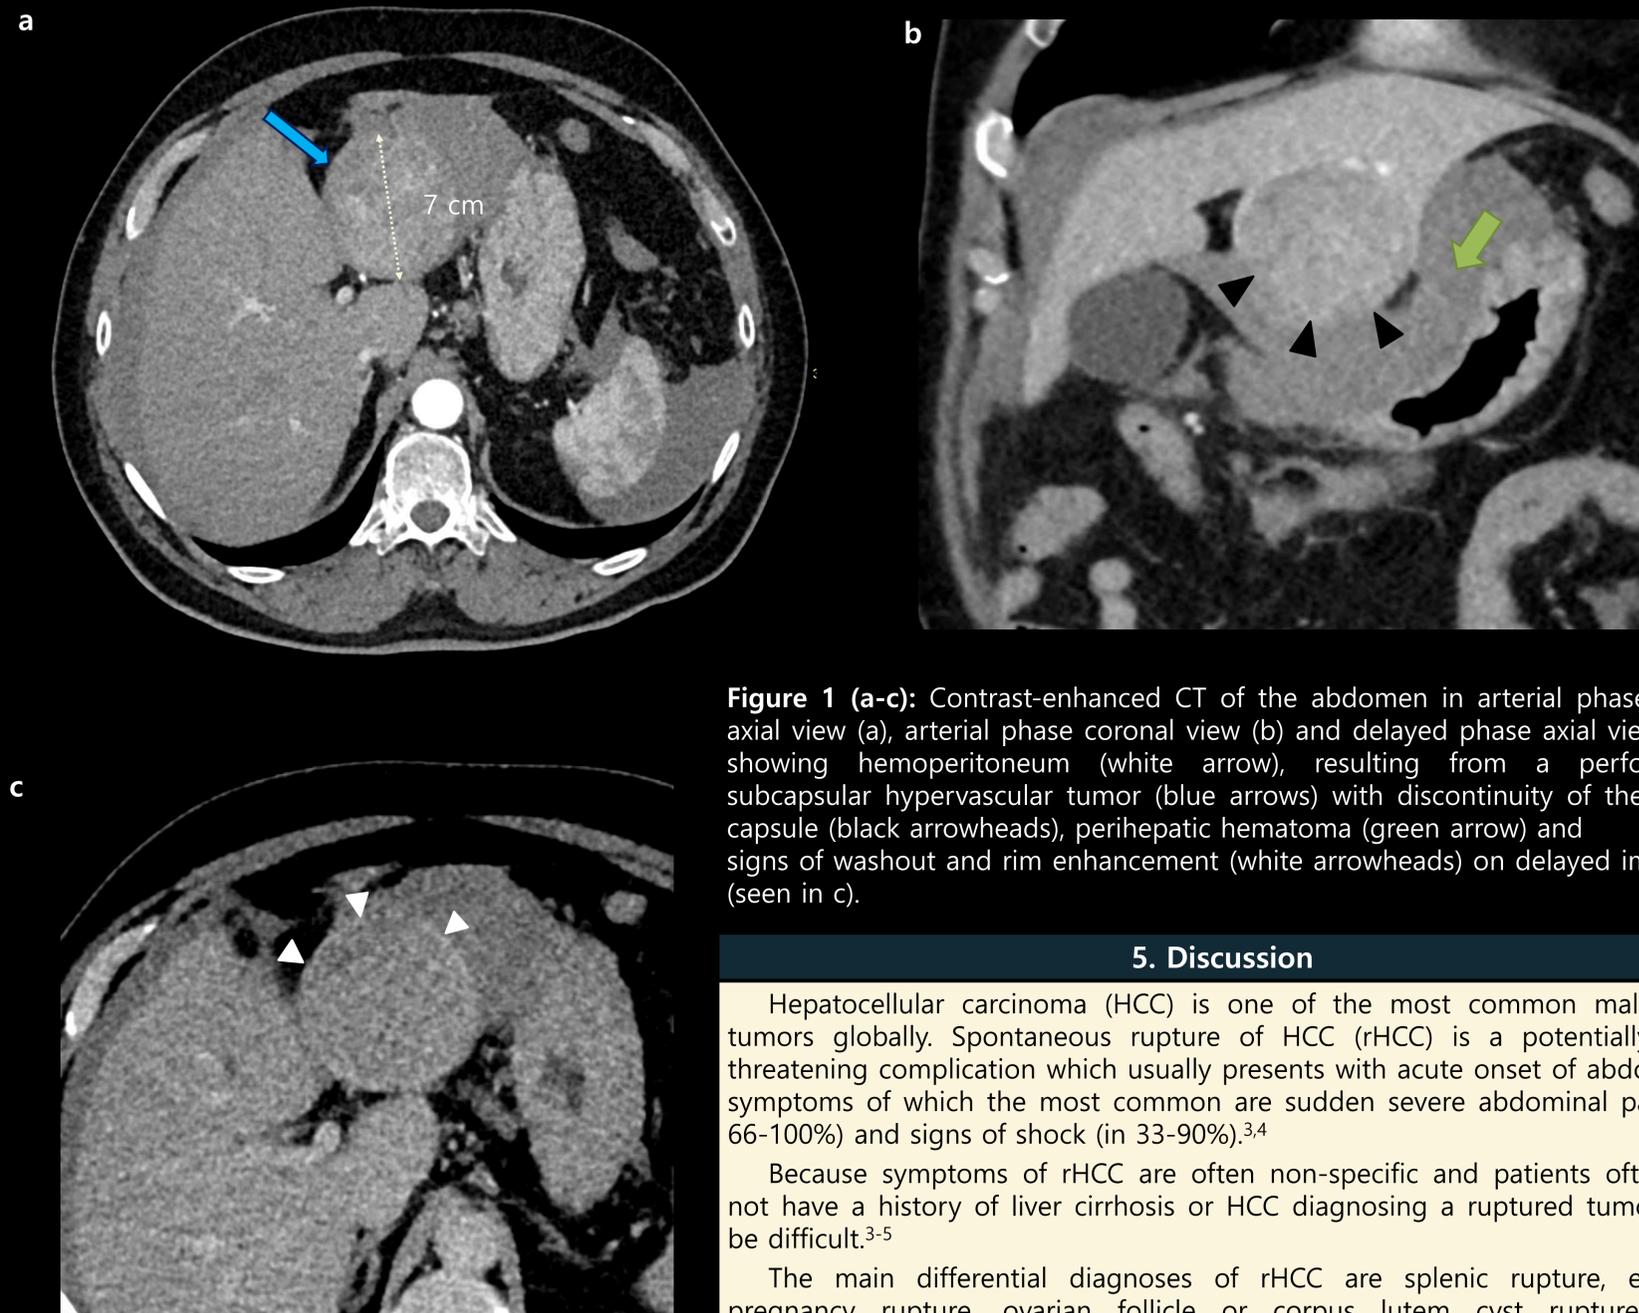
(a-c): Contrast-enhanced CT of the abdomen in arterial phase and axial view (a), arterial phase coronal view (b) and delayed phase axial view (c), showing hemoperitoneum (white arrow), resulting from a perforated subcapsular hypervascular tumor (blue arrows) with discontinuity of the liver capsule (black arrowheads), perihepatic hematoma (green arrow) and signs of washout and rim enhancement (white arrowheads) on delayed images (seen in c).
